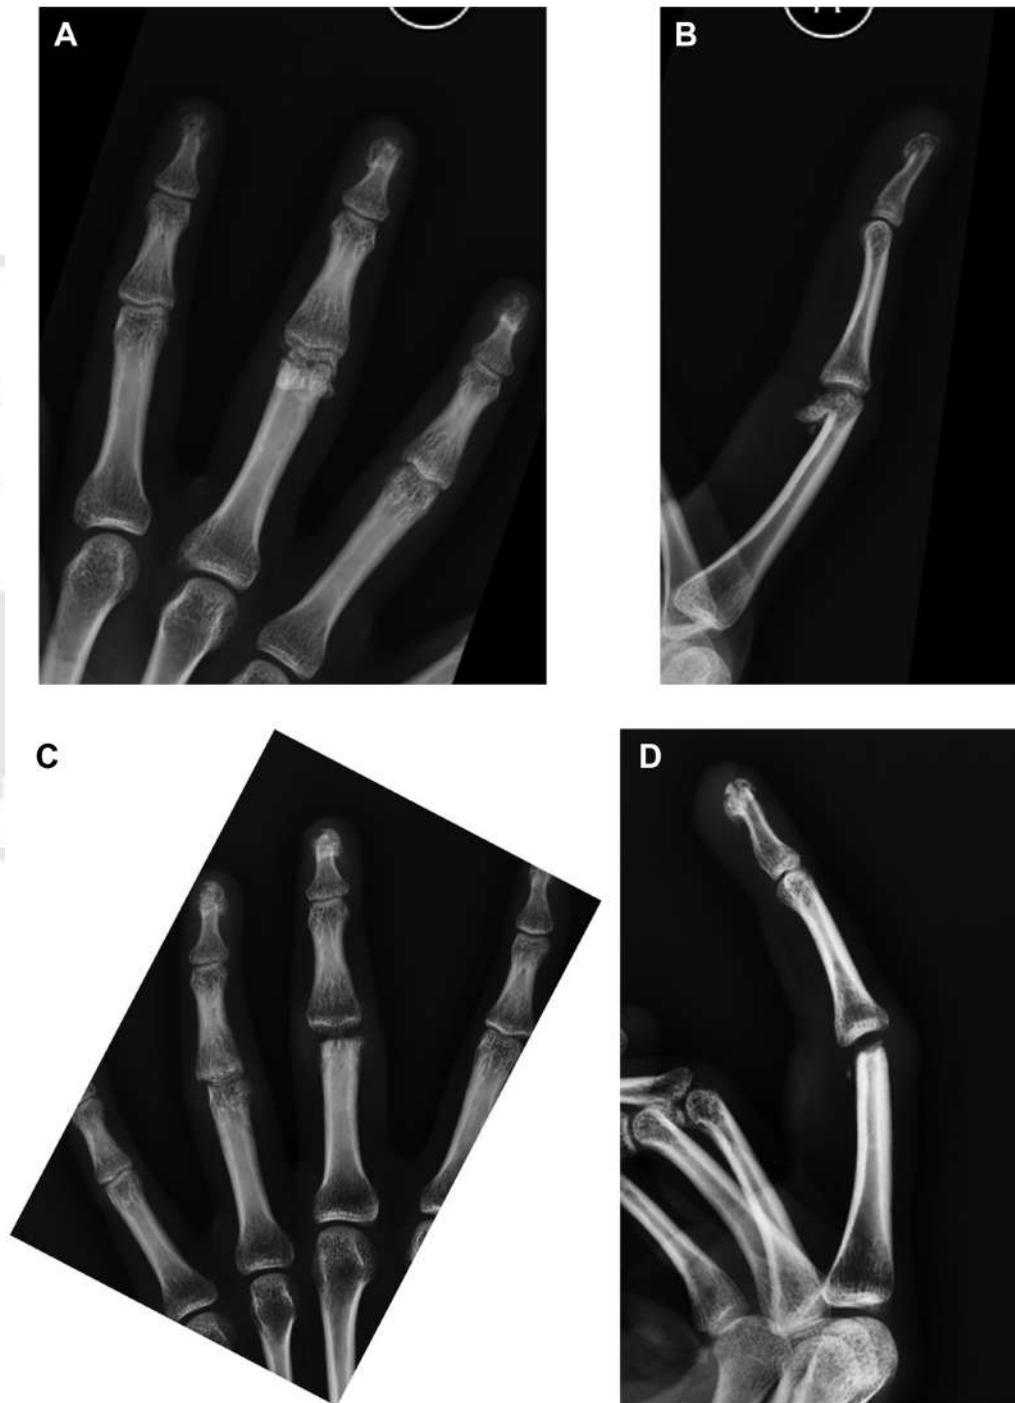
(A) Preoperative Xray AP view. (B) Preoperative xray lateral view. (C) Post operative follow-up xray AP view. (D) Post operative follow-Up xray lateral view.
